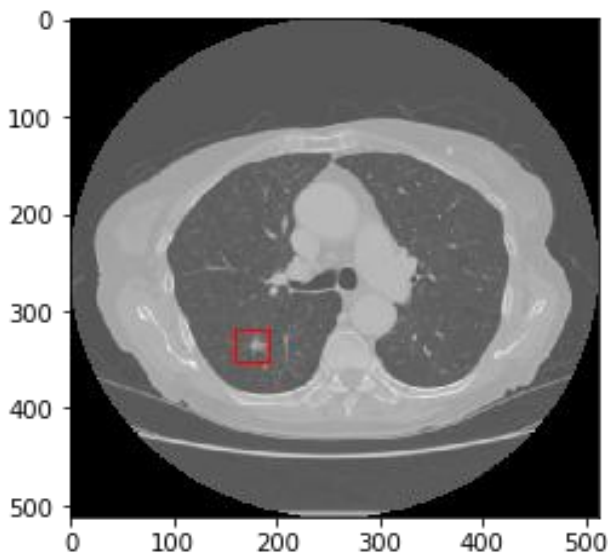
Slice of pulmonary CT scan. Red box shows the lung nodule.
